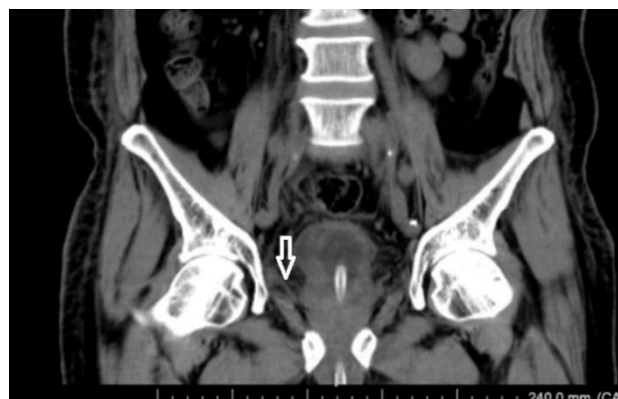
Postoperative coronal CT showing the resolution of right-sided bladder herniation (white arrow) following a combination of mesh repair and open transvesical prostatectomy
